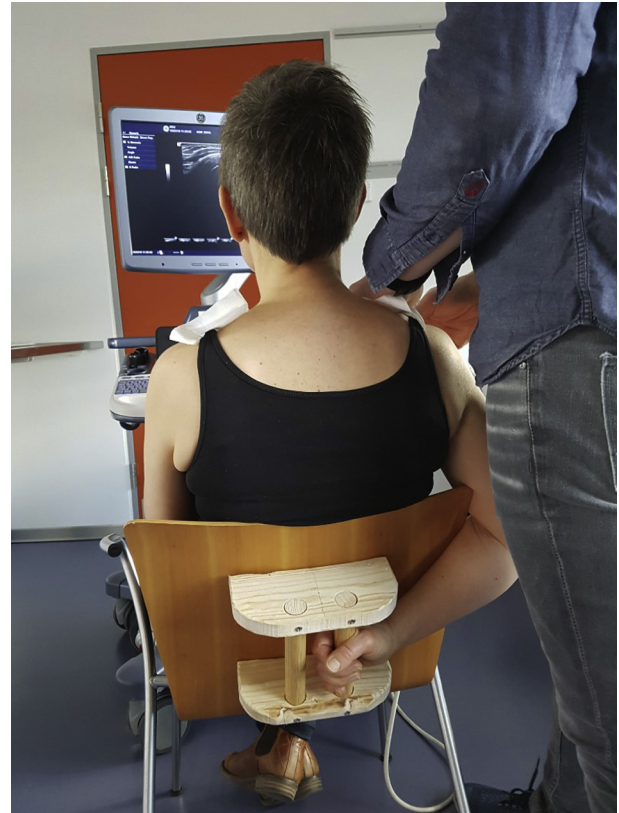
Strain elastography and conventional ultrasound (tendon thickness) were performed while the participant was sitting in a custom-made chair with the selected upper limb fixed in a standardized position.
